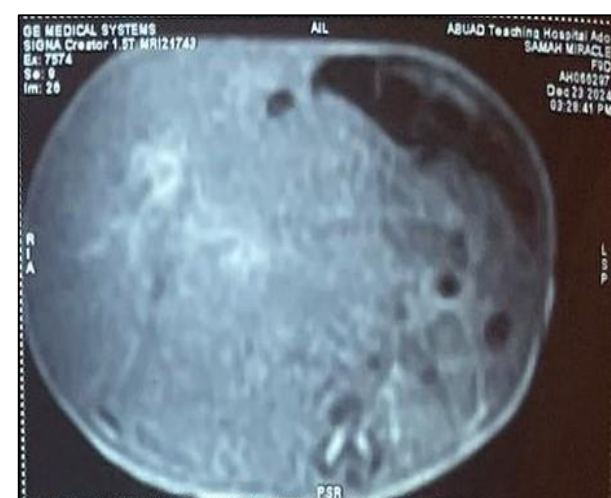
The magnetic resonance imaging (MRI) showing the liver metastasis.
